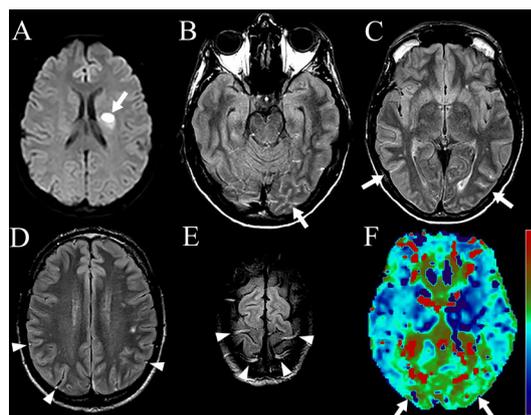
MRI showing (arrows) acute infarction on diffusion weighted imaging (DWI) (A), bilateral subarachnoid (B, C) and meningeal vein (D, E) hyperintensities on FLAIR, and bilateral occipital perfusion deficit (time-to-peak map, (F)).
